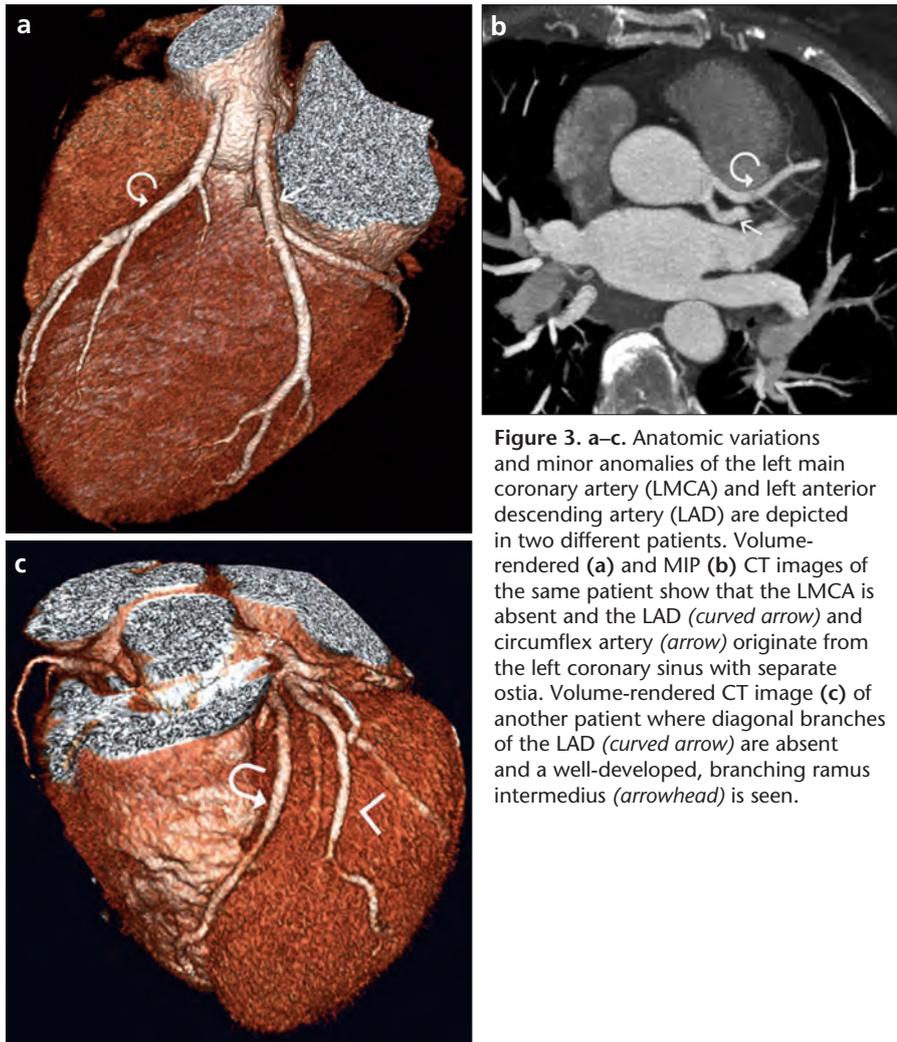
a–c. Anatomic variations and minor anomalies of the left main coronary artery (LMCA) and left anterior descending artery (LAD) are depicted in two different patients. Volume-rendered (a) and MIP (b) CT images of the same patient show that the LMCA is absent and the LAD (*curved arrow*) and circumflex artery (*arrow*) originate from the left coronary sinus with separate ostia. Volume-rendered CT image (c) of another patient where diagonal branches of the LAD (*curved arrow*) are absent and a well-developed, branching ramus intermedius (*arrowhead*) is seen.
